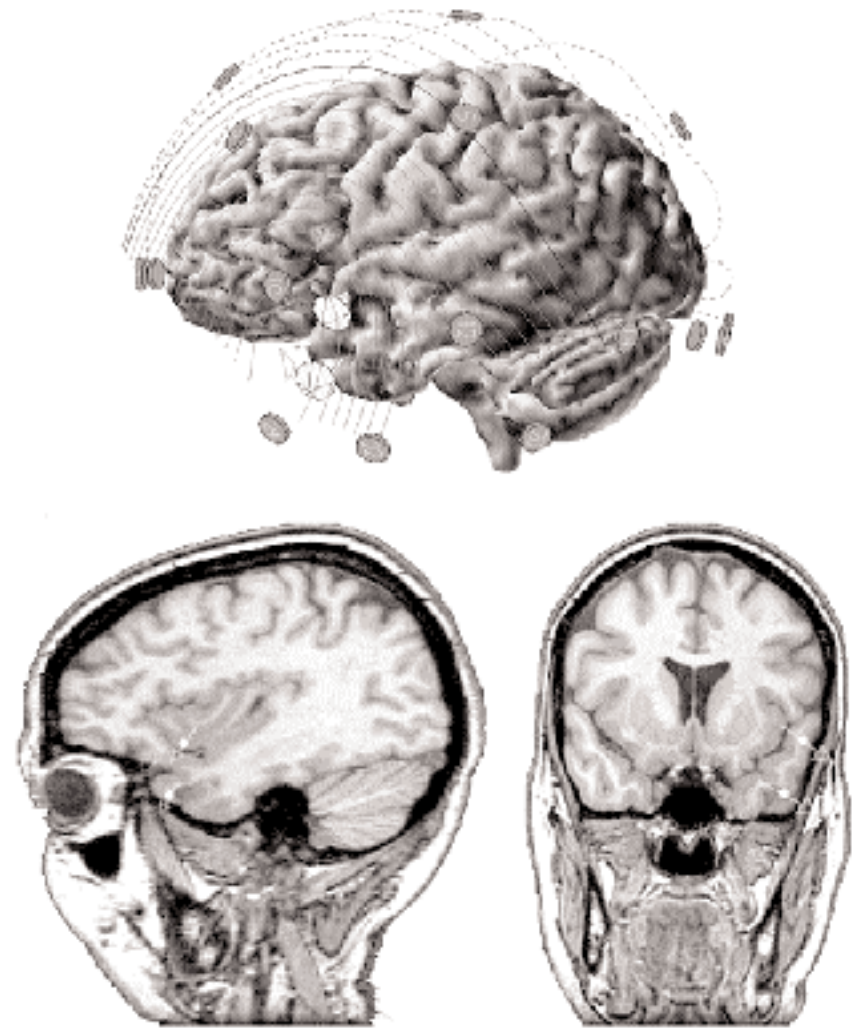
Dipole models of the spike in Figure 23.17, calculated with spherical and realistic BEM head models, are co-registered with three-dimensional (top) and two-dimensional MRI sections of the patient's brain. The dipole model derived from a spherical head model is displaced approximately 2.5 cm above that obtained with a realistic head model. The actual spike source is the cortex surrounding the cystic lesion adjacent to the lower dipole.
